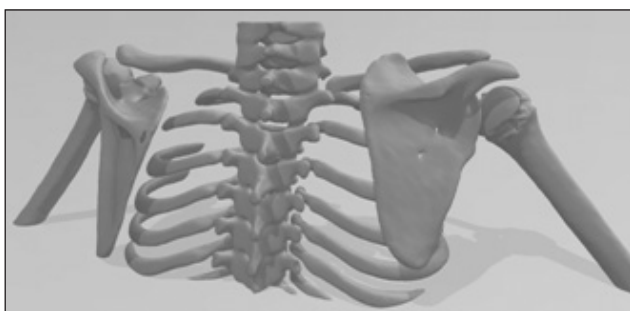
3D image obtained from the patient's CT scan
